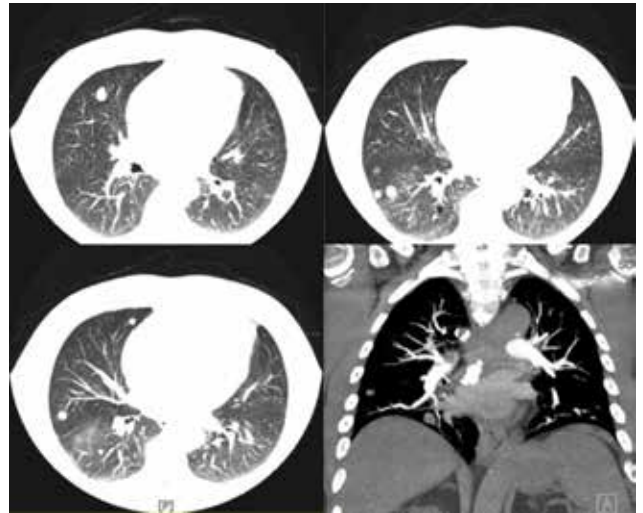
Thorax CT images shows bilateral lung metastasis.
